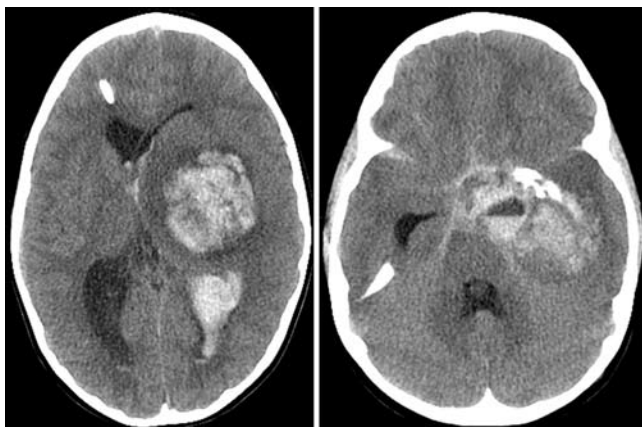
Unenhanced axial CT scans of the brain after initial placement of ventriculostomy. These scans demonstrate a large hemorrhagic mass with substantial subfalcine herniation, transtentorial herniation, and brainstem compression.
